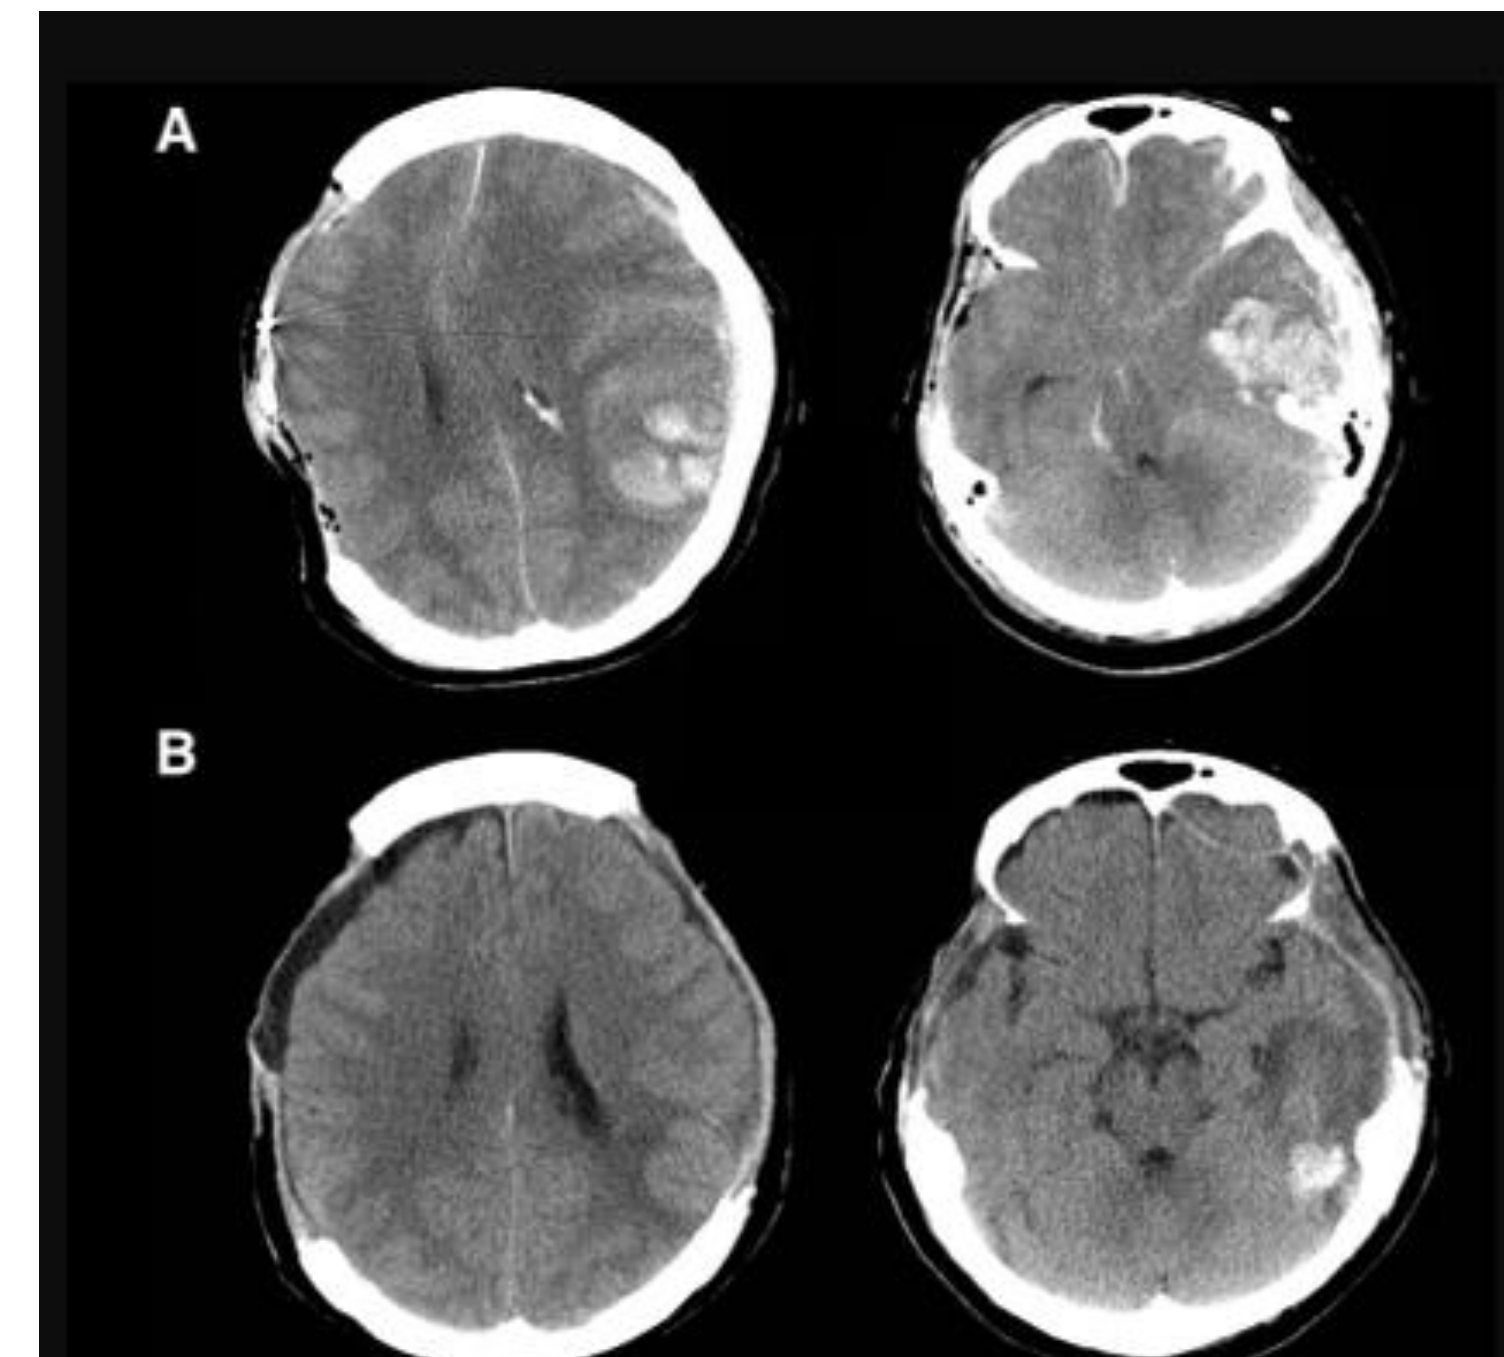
A case of left temporal TICH treated with craniectomy and ,minimally-invasive surgery with ICP insertion. Pre- (A) and post- (B) operative CT scans of case 2: TICH with severe brain swelling.
